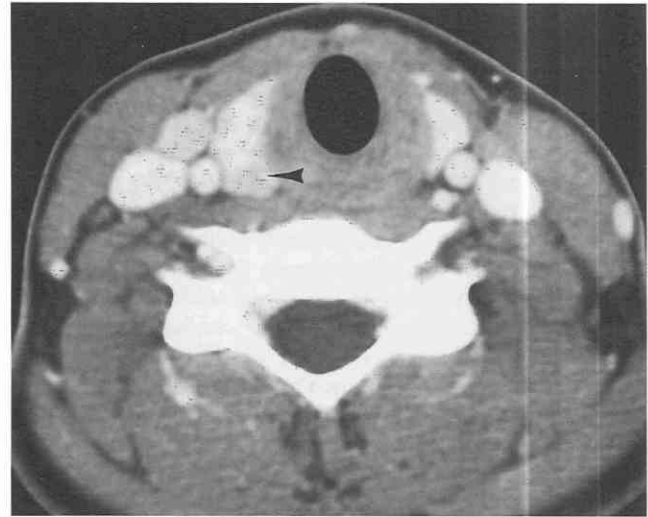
Thyroid carcinoma. Axial postcontrast CT scan. A subtle area of relatively decreased attenuation is noted in the posterior aspect of the right lobe of the thyroid gland.
